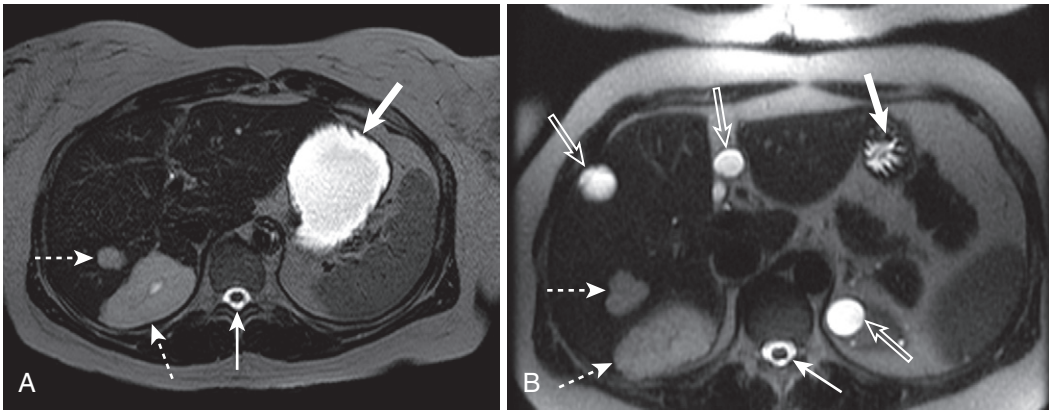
Heavily T2-weighted imaging shows free water. A and B, The heavily T2-weighted images depict free water protons preferentially, at the expense of solid tissue contrast. Solid tissues with bound water molecules, such as the liver, lack signal, whereas structures with free water exhibit marked hyperintensity proportional to their water content. Pure free water molecules found in cerebrospinal fluid (*arrows*), gastrointestinal contents (*thick arrows*), gallbladder (*open arrow*), and simple renal and hepatic cysts define maximum signal intensity, whereas lesions with intermediate free water content, such as hemangiomas (*dashed arrows*) appear moderately hyperintense.
